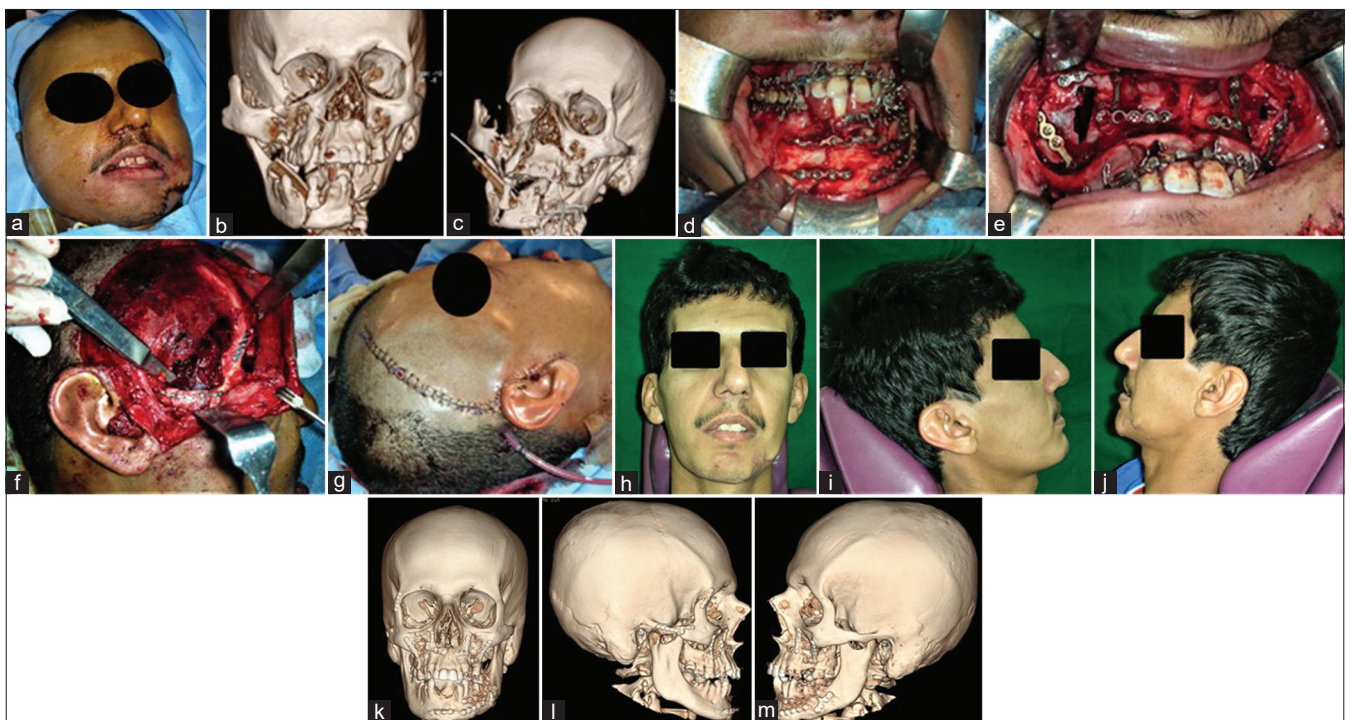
(a) Preoperative photograph of the patient with panfacial fractures. (b) Preoperative three-dimensional reconstructed computed tomography scan view of severe comminuted panfacial fractures associated with fractured zygomatic complex which required repair using the sequence of “bottom-up and outside-in” approach. (c) Preoperative three-dimensional reconstructed computed tomography scan view of severe comminuted panfacial fractures associated with fractured zygomatic complex which required repair using the sequence of “bottom-up and outside-in” approach. (d) Intraoperative photograph of the same patient showing ORIF of the comminuted mandibular fractures (e) Intraoperative photograph of the same patient showing ORIF of the comminuted maxillary fractures (f) Intraoperative photograph of the same patient showing ORIF of comminuted fractures of right zygomatic complex through uni-coronal approach. (g) Intraoperative photograph of the same patient showing closure of uni-coronal flap under vacuum drainage. (h-j) Six months’ postoperative frontal view, right and left lateral view of same patient, (k-m) Six months’ postoperative three-dimensional reconstructed computed tomography scan showing anterior posterior view, right and left lateral view of same patient.
